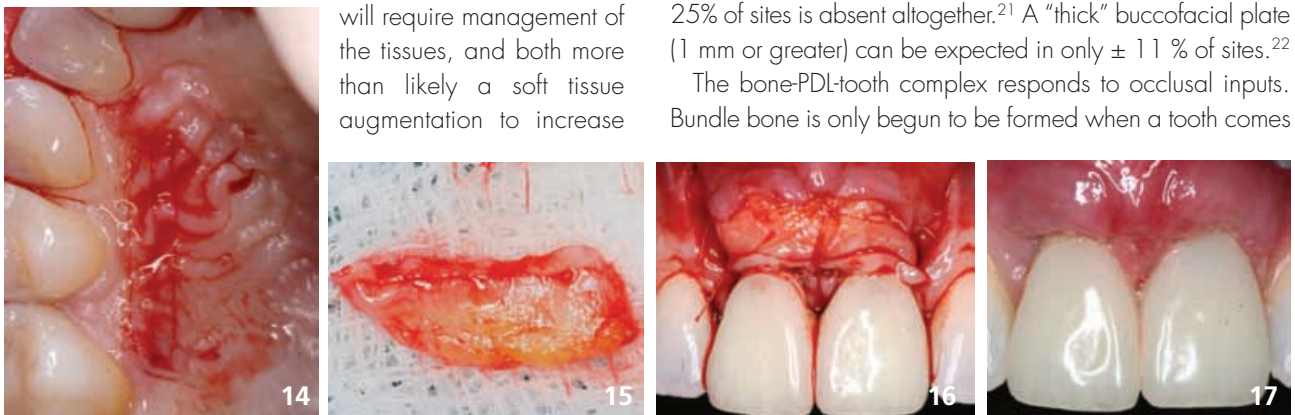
2006 - Parallel incisions in the anterior palate to harvest the CT graft
